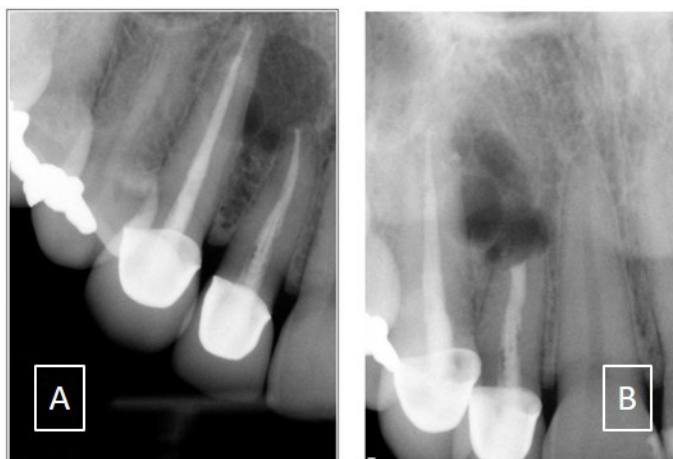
Periapical image taken in December 2011 (left) and in February 2012 (right) showing a multilocular radiolucency in teeth 13 and 12 sites. The left image was taken after endodontic therapy on teeth 13 and 12. The right image was taken following an apicoectomy on tooth 12.
